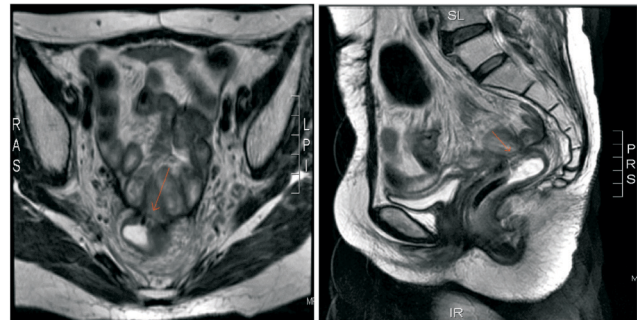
Abdominal and pelvic MRI showed fistula of small bowel to stump of upper rectum.
